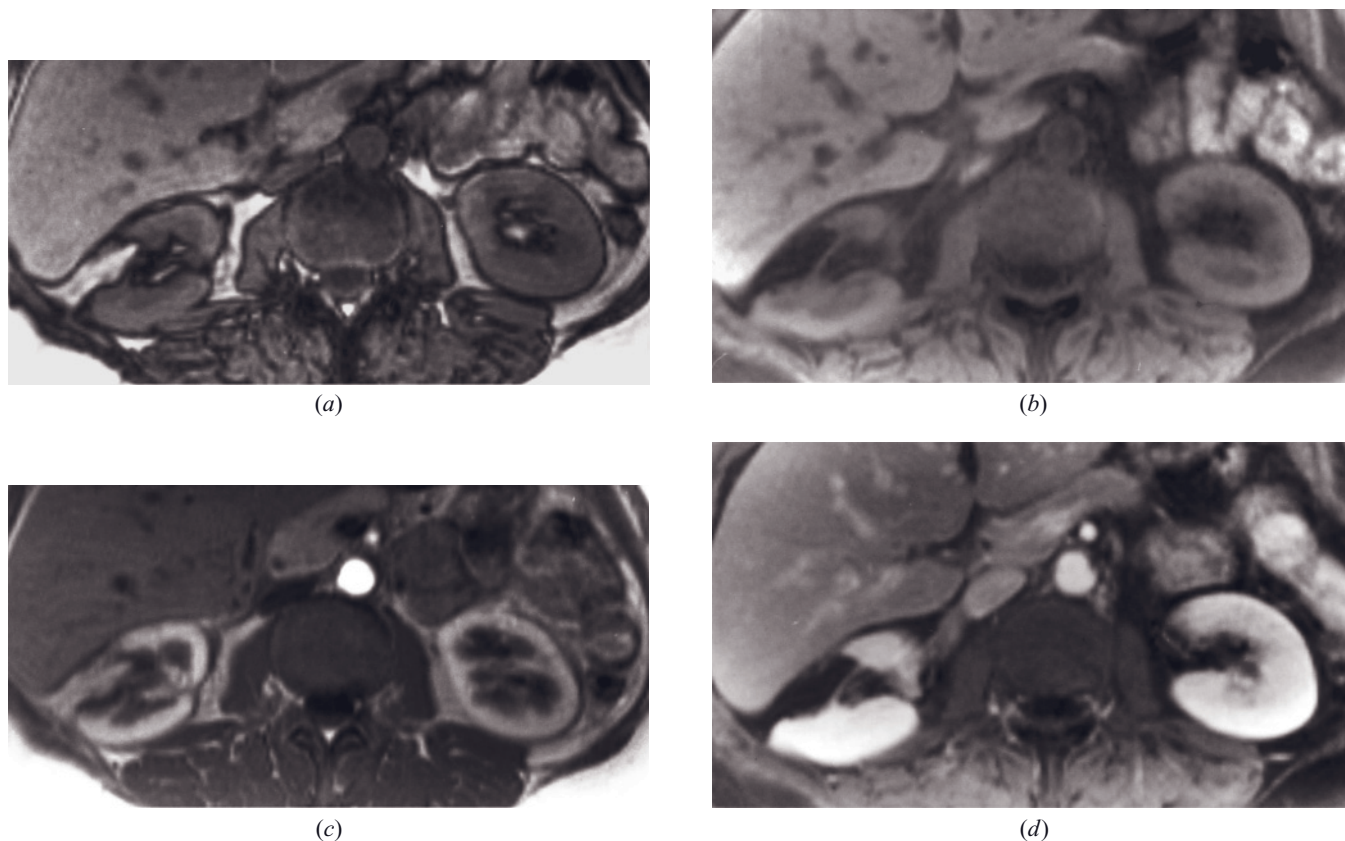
Segmental nephrectomy. T1-weighted out-of-phase (a), fat-suppressed (b), and immediate (c) and 90-s fat-suppressed (d) postgadolinium SGE images. There is a surgical defect in the midpole of the right kidney that has been filled by perirenal fat.
